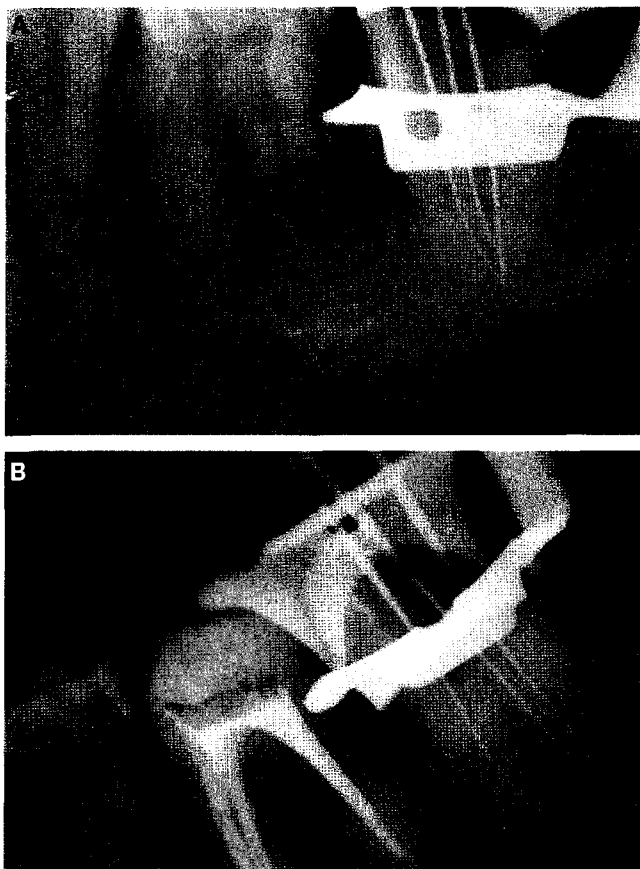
Radiograph with files to working length. (A) Instruments tend to converge at the apex. (B) Some instruments seem to perforate the furcation.
